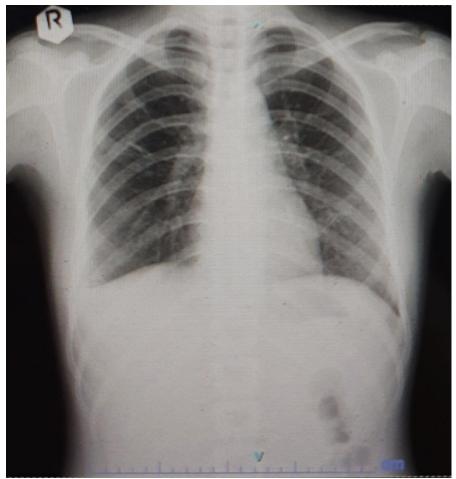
Chest X-ray examination after 2 months of TB treatment showed significant improvement.
